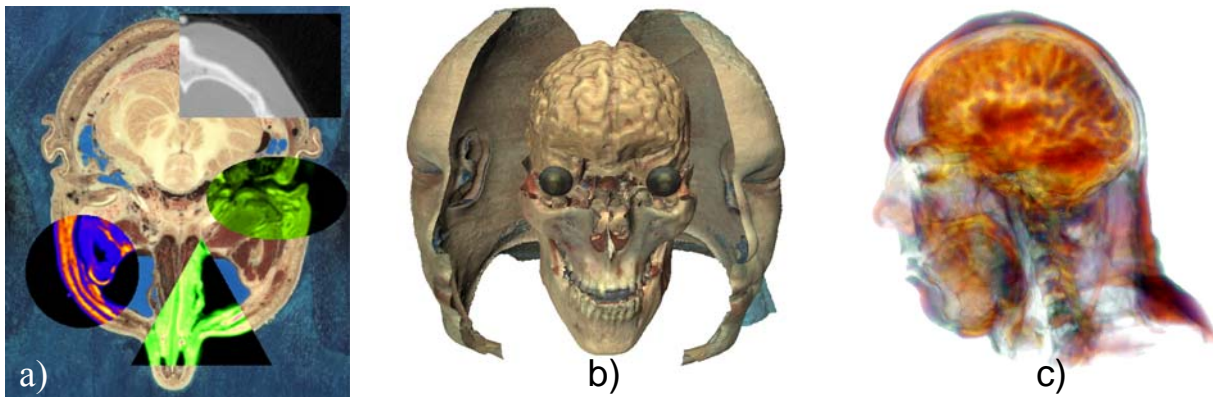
Different instances of the virtual anatomical model. Various inspection windows in the cross-section view of the registered MR, CT and RGB VHP datasets (a). Exploration of the model can be done using different visualization and manipulation tools, like surface rendering and cutting tools (b) or volume rendering (c).
